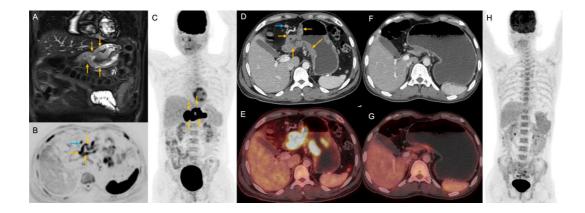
Stage IIE on both WB-MRI and PET-CT. A. Coronal STIR image showing hyperintense diffuse asymmetric wall thickening (yellow arrows) involving the lesser and greater curvatures of the distal body and pyloric regions of the stomach. B. Axial DWI image showing diffusion restricting asymmetric wall thickening (yellow arrows) involving the lesser and greater curvatures of the distal body and pyloric regions of the stomach. Diffusion restricting the peri-gastric lymph node (blue arrow) is also seen. C. Coronal MIP DWI image showing diffusion restricting asymmetric wall thickening (yellow arrows) involving the lesser and greater curvatures of the distal body and pyloric regions of the stomach. D & E. Axial CECT and PET-CT images showing FDG avid asymmetric wall thickening (yellow arrows) involving the lesser and greater curvatures of the distal body and pyloric regions of the stomach. A round, homogeneously enhancing peri-gastric lymph node (blue arrow on D) is seen, which is likely involved in the disease. However, it does not show FDG uptake. F, G & H. Axial CECT, PET-CT and MIP PET-CT images of the scan done after 3 months, show total resolution of the disease. There is a mild increase in FDG uptake in the axial and appendicular skeleton – likely due to marrow reactivation.
